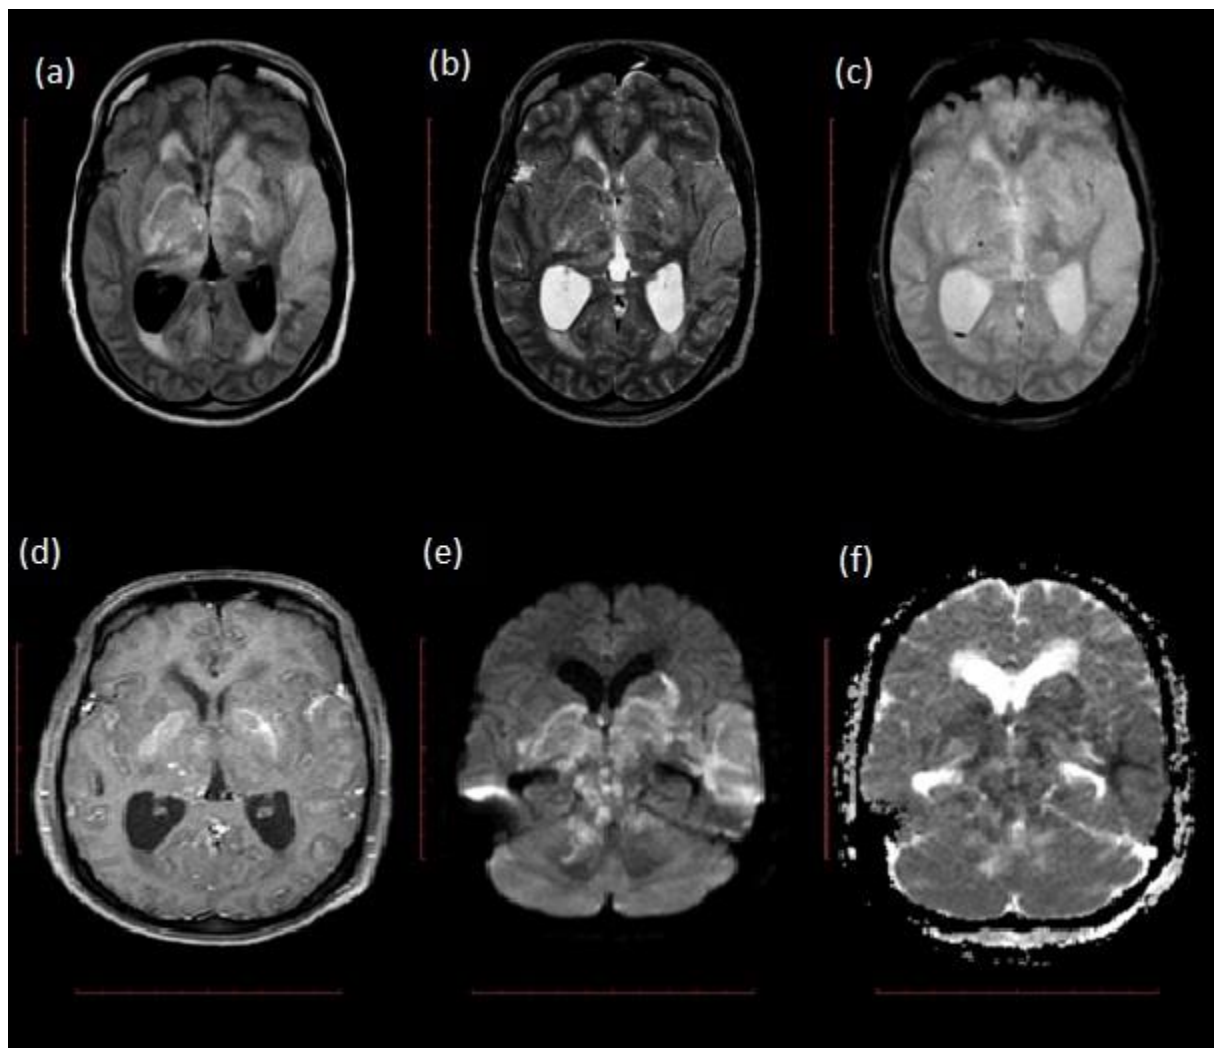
Dengue Encephalitis: Axial T2/FLAIR images show hyperintense signal in bilateral thalamic and lentiform nucleus and in left temporal lobe (a,b), No blooming in axial FFE image (c), contrast enhancement in axial T1 postcontrast image (d), restrictive diffusion in axial DWI/ADC image (e,f).
